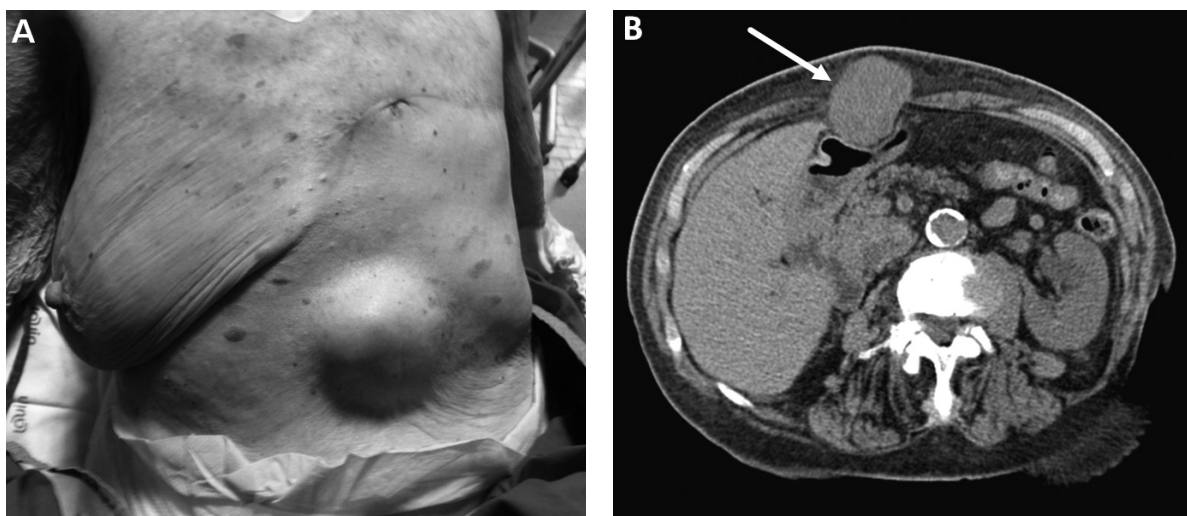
A*, Picture demonstrating the clinical presentation of the metastasis. *B*, Abdominal CT scan showing a 6 × 5 cm mass in the subcutaneous layer of middle upper abdomen, causing an extrinsic compression of the stomach.
